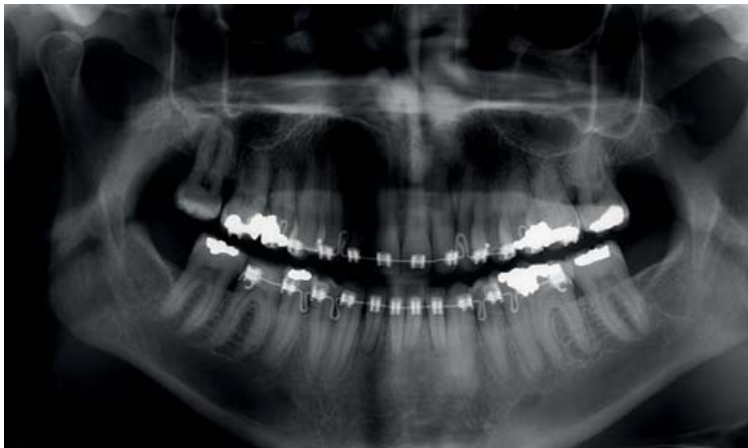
Preoperative orthopantomographic image acquired a month before bilateral sagittal split osteotomy (BSSO).
